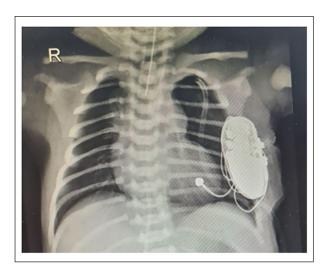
An anteroposterior X-ray of a I-day-old boy after a pacemaker implantation.
